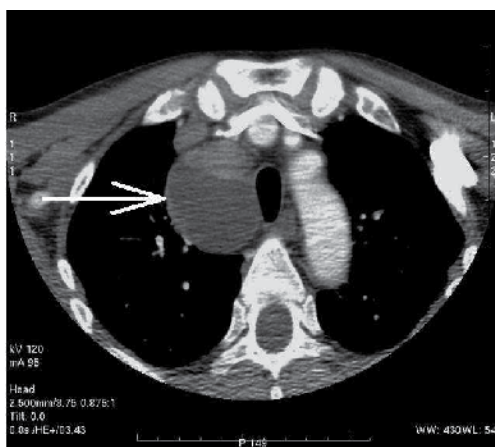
Computed tomography scan showing a large mediastinal parathyroid adenoma (indicated with an arrow)
